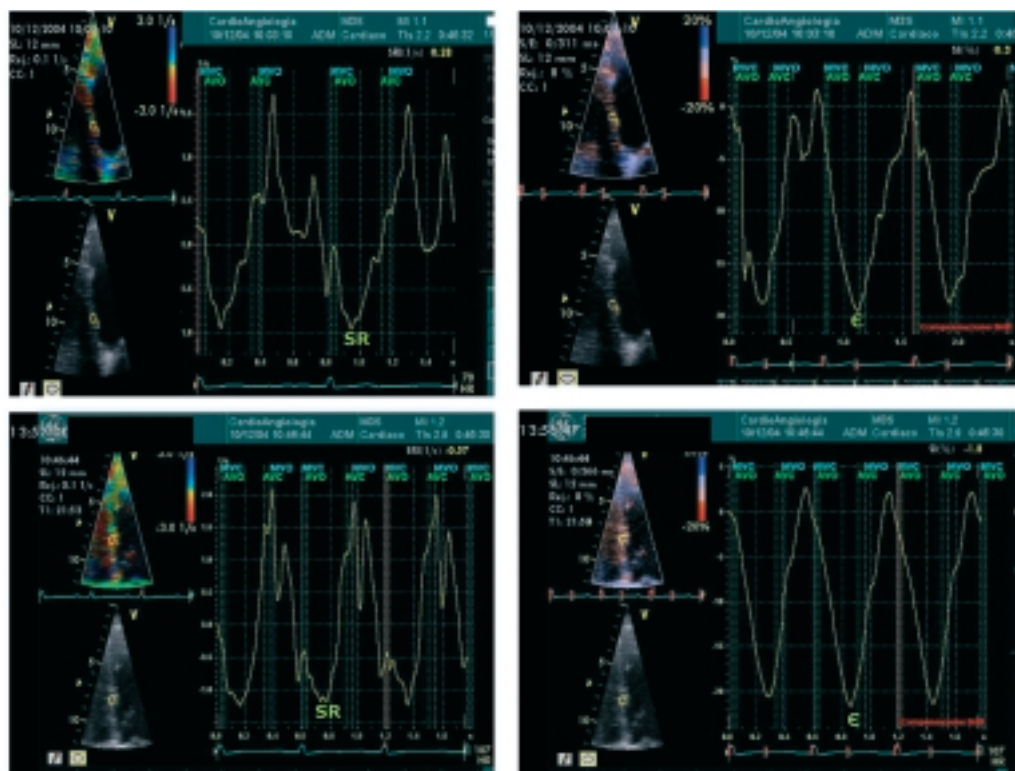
Strain rate (SR) and strain (ϵ) at rest (upper panel, left and right respectively) and during dobutamine stress echocardiography (lower panel, left and right respectively). An increase of both SR (from 1.00 to 1.3 s^{-1}) and ϵ (from 18.0 to 23.0%) respectively is detected from resting conditions (heart rate 70-71 b/min) to dobutamine infusion (heart rate 102 b/min). End-diastole and end-systole are identified superimposing markers of mitral valve opening (MVO) and closure (MVC) by standard Doppler mitral inflow imaging (apical 4-chamber view) and markers of aortic valve opening (AVO) and closure (AVC) by standard Doppler left ventricular out-tract systolic flow (apical 5-chamber view). The measure of both ϵ and SR are performed at end-systole.
